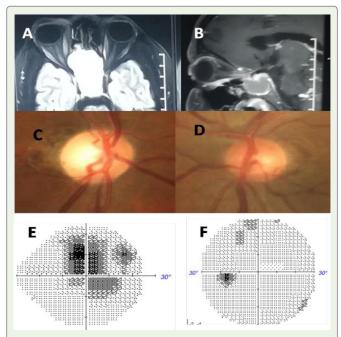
T1W image of MRI of brain and orbits (axial cut)showing large expansile cystic lesion in sphenoid sinus involving onodi cells and extending into bilateral posterior ethmoidal cells and right orbital apex compressing over intra canalicular part of right optic nerve(A). MRI orbit sagittal cut post contrast showing abnormal enhancement in intra-canalicular part of right optic nerve and rim enhancement of cystic lesion n(B). Color fundus photo (CFP) of right eye after surgery showing temporal pallor of optic disc (C). CFP of left eye showing apparently healthy looking disc(D). Right eye HVF 24-2 with size 5 target showing central scotoma (E) Left eye HVF 30-2 with size 3 target showing normal field at presentation (F)
